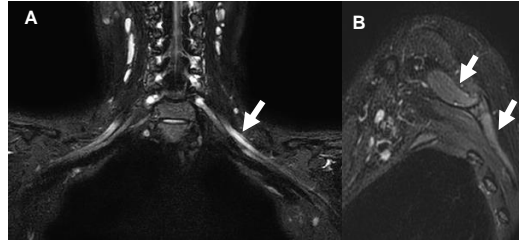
Brachial plexus MRI showed high signal intensity of upper, middle, lower trunk (A, arrow) with denervation edema in supraspinatus, infraspinatus muscle (B, arrow).
